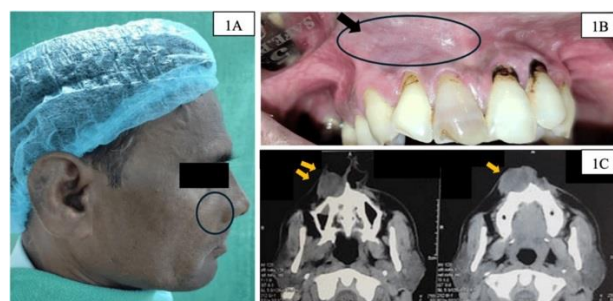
Extraoral, intraoral and radiological view; A: Photograph of patient showing diffuse swelling in right naso-alar region (marked with black arrow); B: Intraoral photograph showing obliteration of right labial vestibule and swelling with bluish pink hue (marked with black arrow); C: CT axial view showing extraosseous portion of cyst causing saucerization of buccal plate of maxilla (marked with yellow arrows)
